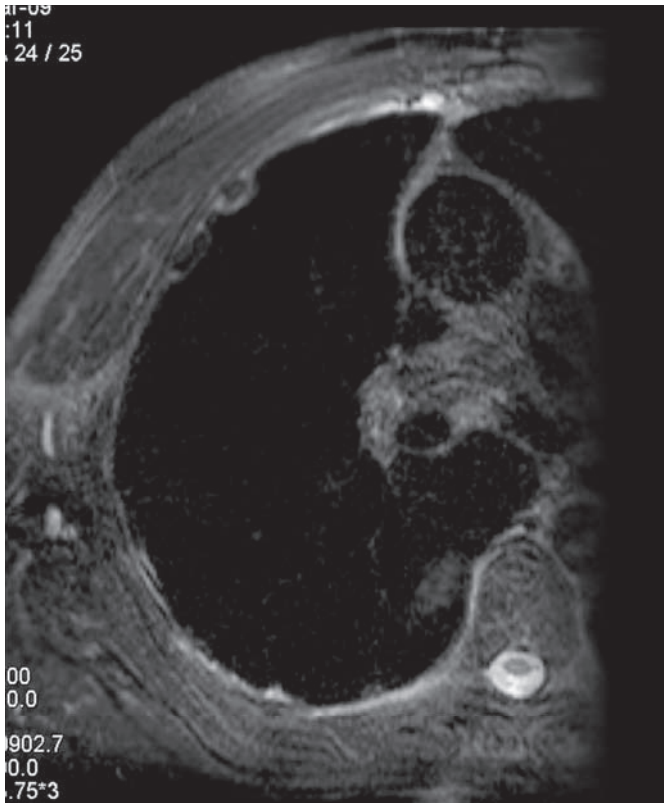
A, B. MRI and CT images of the same patient. (A) T2 fs-weighted MRI image in axial plane shows benign hypo-intense pleural plaques with hyper-intense rim. (B) On CT image calcification on the lateral side of the plaques are more delineated than on MRI images.
